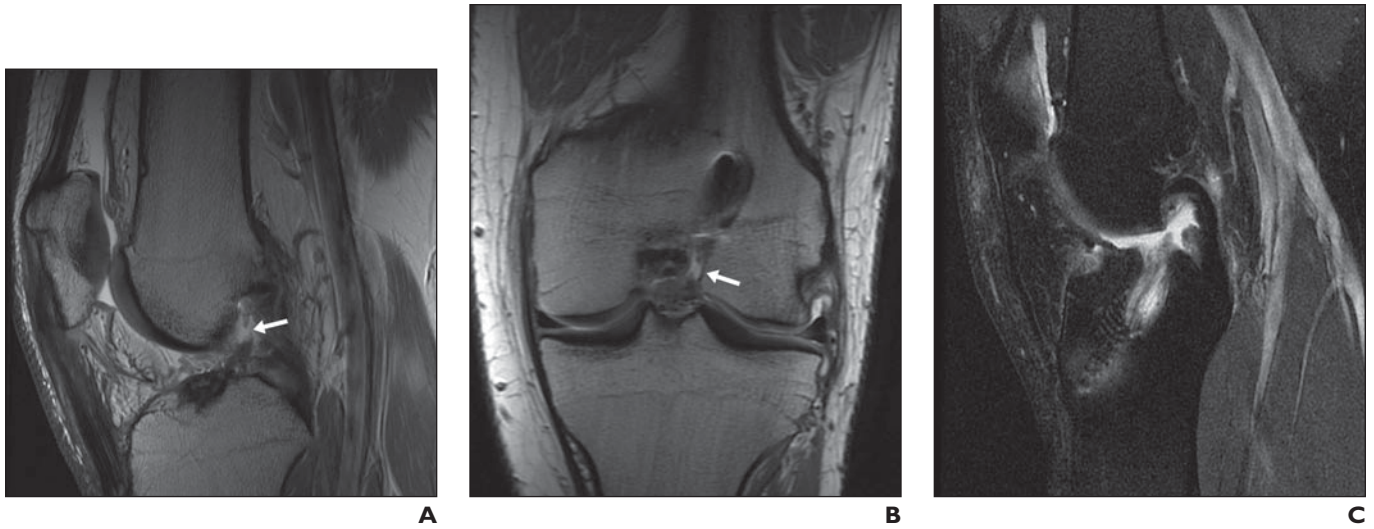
Graft tear in 19-year-old man who presented for follow-up imaging after anterior cruciate ligament (ACL) reconstruction. A and B, Sagittal (A) and coronal (B) T1-weighted MR arthrograms show complete discontinuity of fibers of ACL graft with intervening contrast material (*arrows*). C, Sagittal T2-weighted fat-suppressed MR image shows complete discontinuity of graft, which is replaced with fluid signal.
